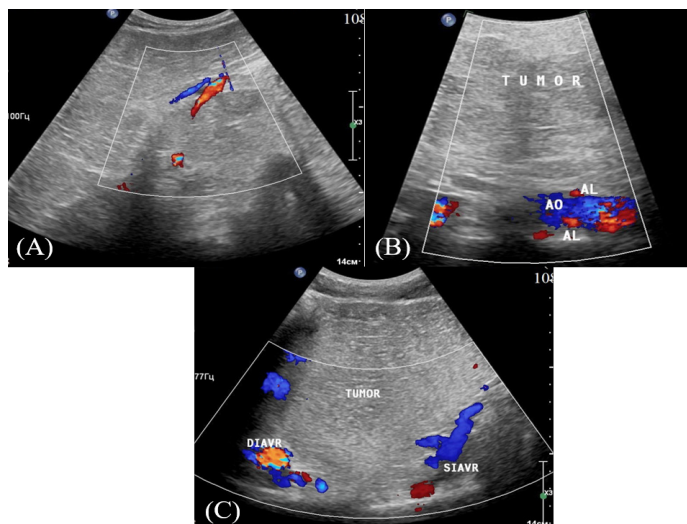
Ultrasound images of retroperitoneal liposarcoma in the color doppler mapping: (a) - the structure of the tumor is shown; (b) - the mass (TUMOR) compresses the aorta (AO), the lumbar arteries (AL), which are involved in the blood supply of the tumor, are identified; (c) - relationship of the tumor (TUMOR) with the branches of the iliac vessels.
